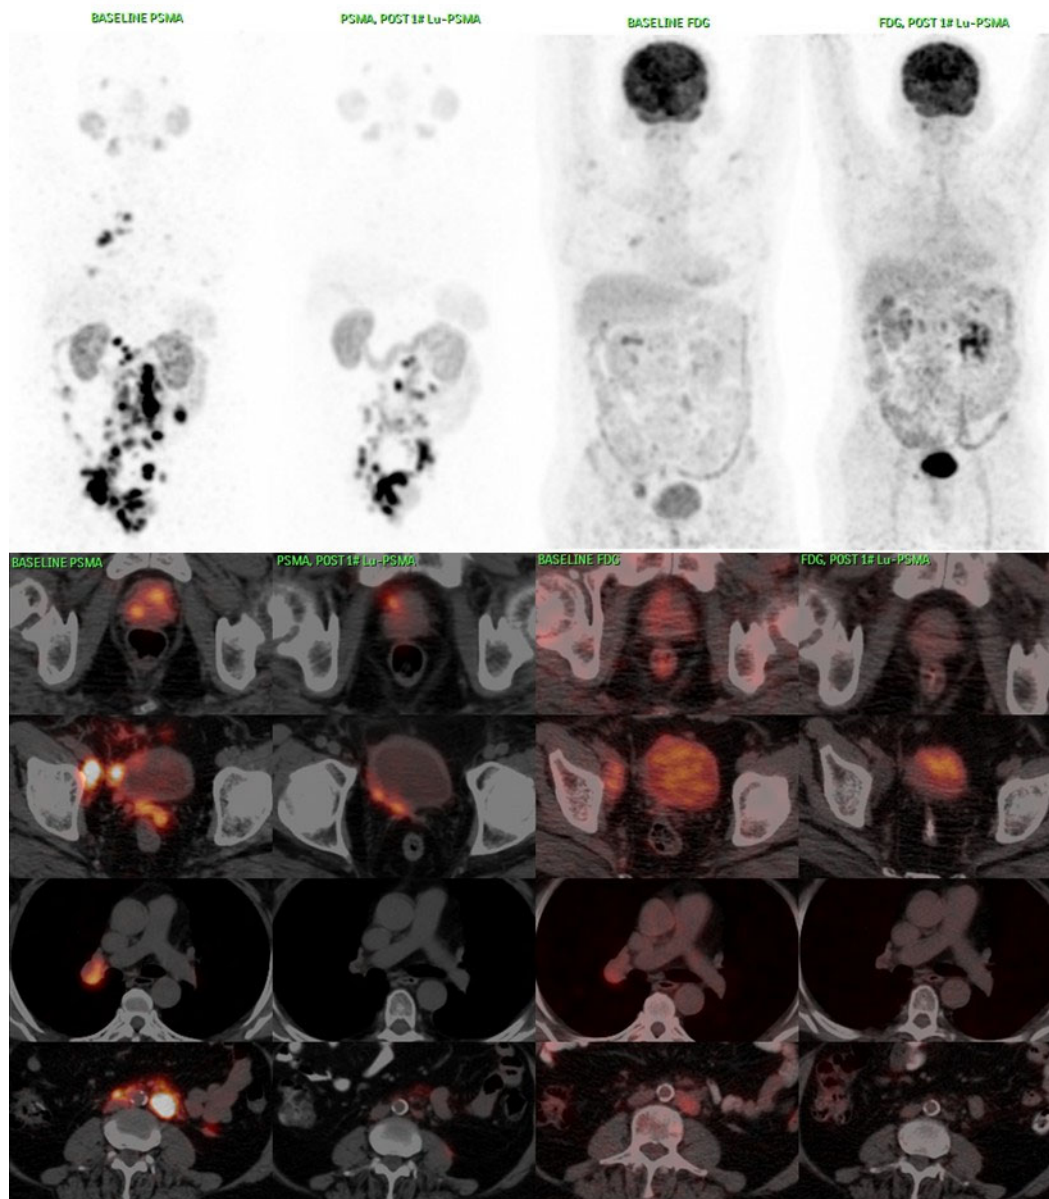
Comparative analysis of  $^{68}\text{Ga}$ -PSMA-11 PET/CT (left sided 2 panels) and FDG-PET/CT (right sided 2 panels) at baseline and post  $^{177}\text{Lu}$ -PSMA-617PRLT of Case III.
